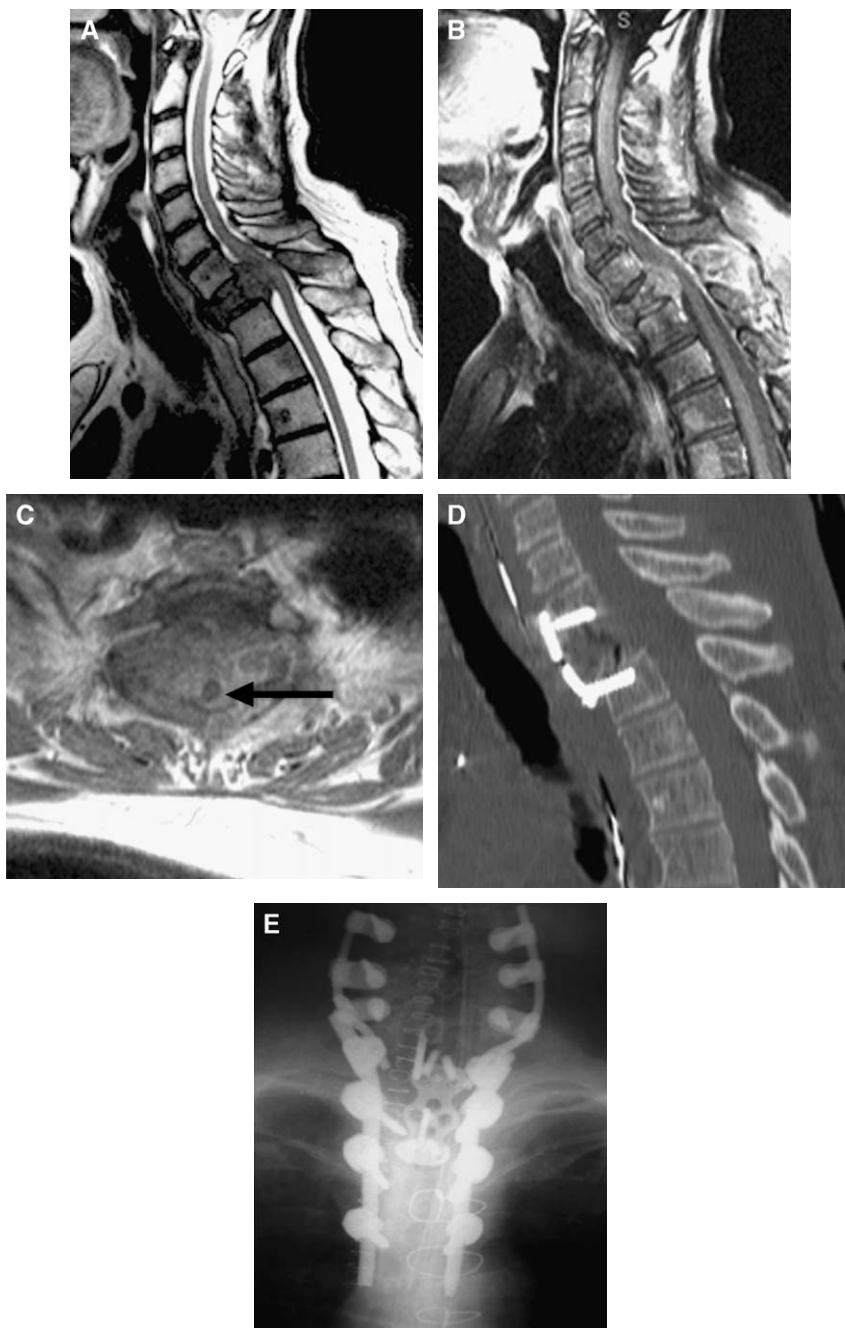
A 73-year-old man with upper thoracic pain for several months presented with a 24-hour history of inability to ambulate. Preoperative sagittal T2-weighted (A) as well as postcontrast sagittal (B) and axial (C) T1-weighted MRI scans show spinal cord (arrow) compression by epidural disease at the T1 spinal level. The patient underwent an emergent T1 vertebrectomy and polymethylmethacrylate (PMMA) reconstruction via an anterior approach (combined anterior neck dissection and median sternotomy). (D) Postoperative CT sagittal reconstructed image shows the ventral plate and screws at C7 to T2. The patient recovered motor function. Prostate carcinoma of the spine was diagnosed. He later underwent T1 laminectomy and posterior instrumented fusion. (E) Postoperative anteroposterior radiograph demonstrates lateral mass screws (C5–C7) and pedicle screws (T2–T4), with a rod connector bridging the cervical and thoracic rods. Steinmann pins securing the PMMA ventrally are also seen.
